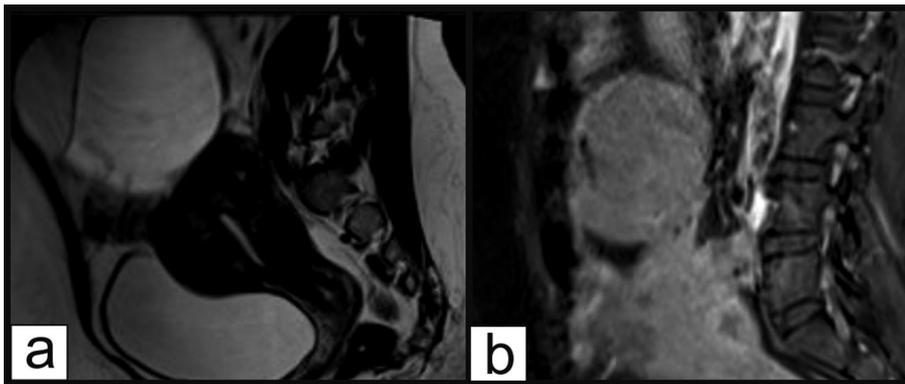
a) the border between the mass and the uterus cannot be distinguished on T2 sagittal magnetic resonance imaging; b) multiple myoma nuclei in the uterine myometrium.
